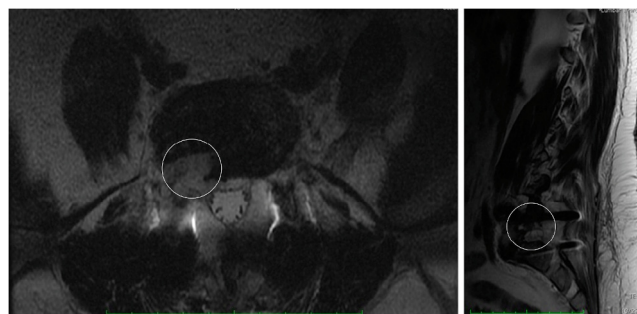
Contrast-enhanced T1-weighted magnetic resonance (MR) images of the lumbar spine, axial (Left) and sagittal (Right) views. The white circle indicates a moderate amount of fluid (7 cm×1.0 cm×0.7 cm) surrounding the thecal sac and posterior to the right TLIF graft extending into the right neural foramen.
